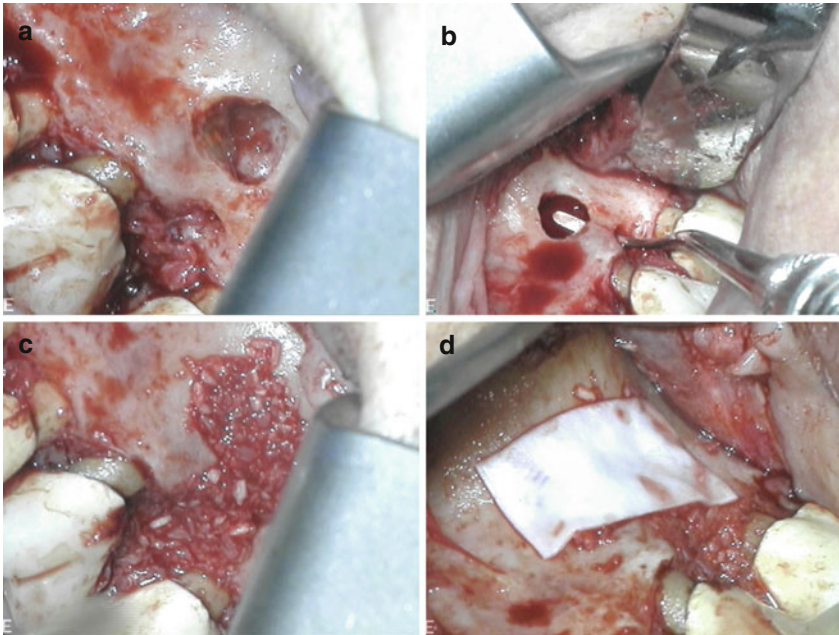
Continuation of case presented in Fig. 6.1: clinical picture after flap reflection showing both crestal and periapical lesions (a). Communication between both defects (b). Both defects grafted with enCore™ combination allograft (Osteogenics Biomedical, Lubbock, TX) (c). CopiOs™ pericardium membrane (Zimmer, Warsaw, IN) (d)
